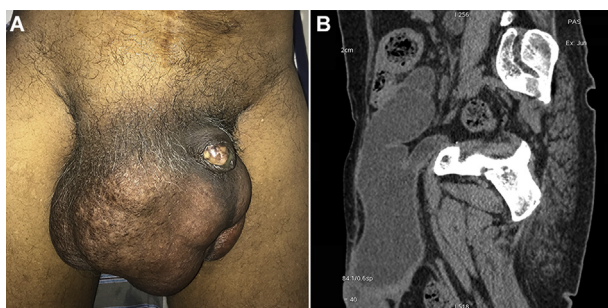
Clinical and CT Scan picture. (A) Clinical examination revealing Inguinoscrotal hernia; (B) Computed tomography revealing neobladder in scrotum along with ileal loop. CT, computed tomography.
